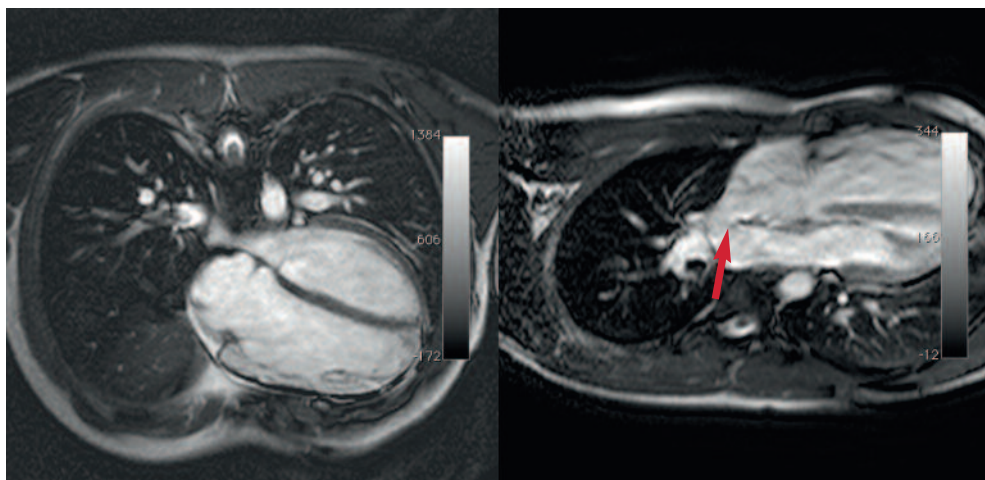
Cardiac MRI showing mild narrowing at previous coarctation repair site.
